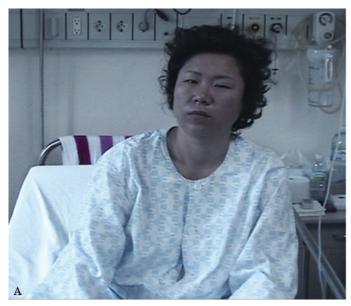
(A) Patient shows leftward truncal lateropulsion and left Horner syndrome. (B) T2-weighted MRI demonstrates acute infarction in the left dorsolateral medulla (arrow).
